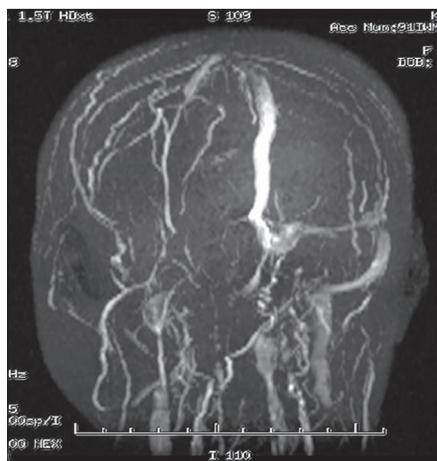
MRI showing right transverse and sigmoid sinus thrombosis up to the confluence and loss of flow related enhancement
